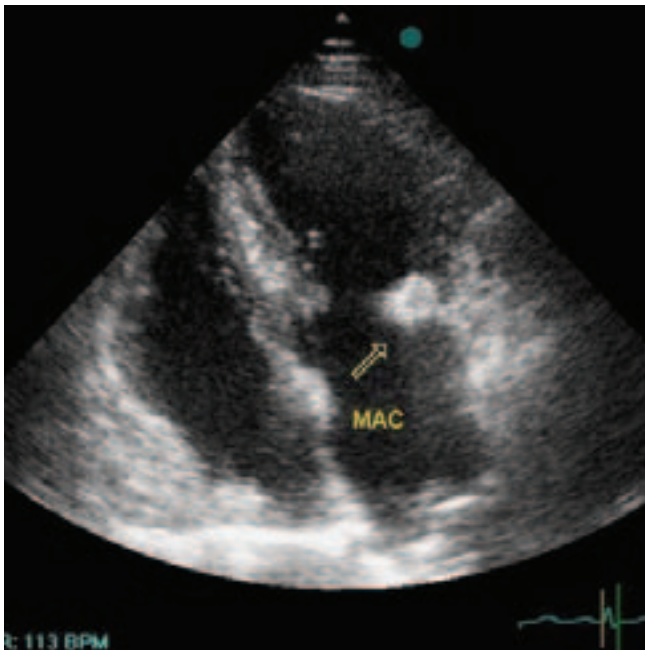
Mitral annular calcification (MAC); apical four-chamber view showing significant calcification of posterior mitral annulus (arrow)
